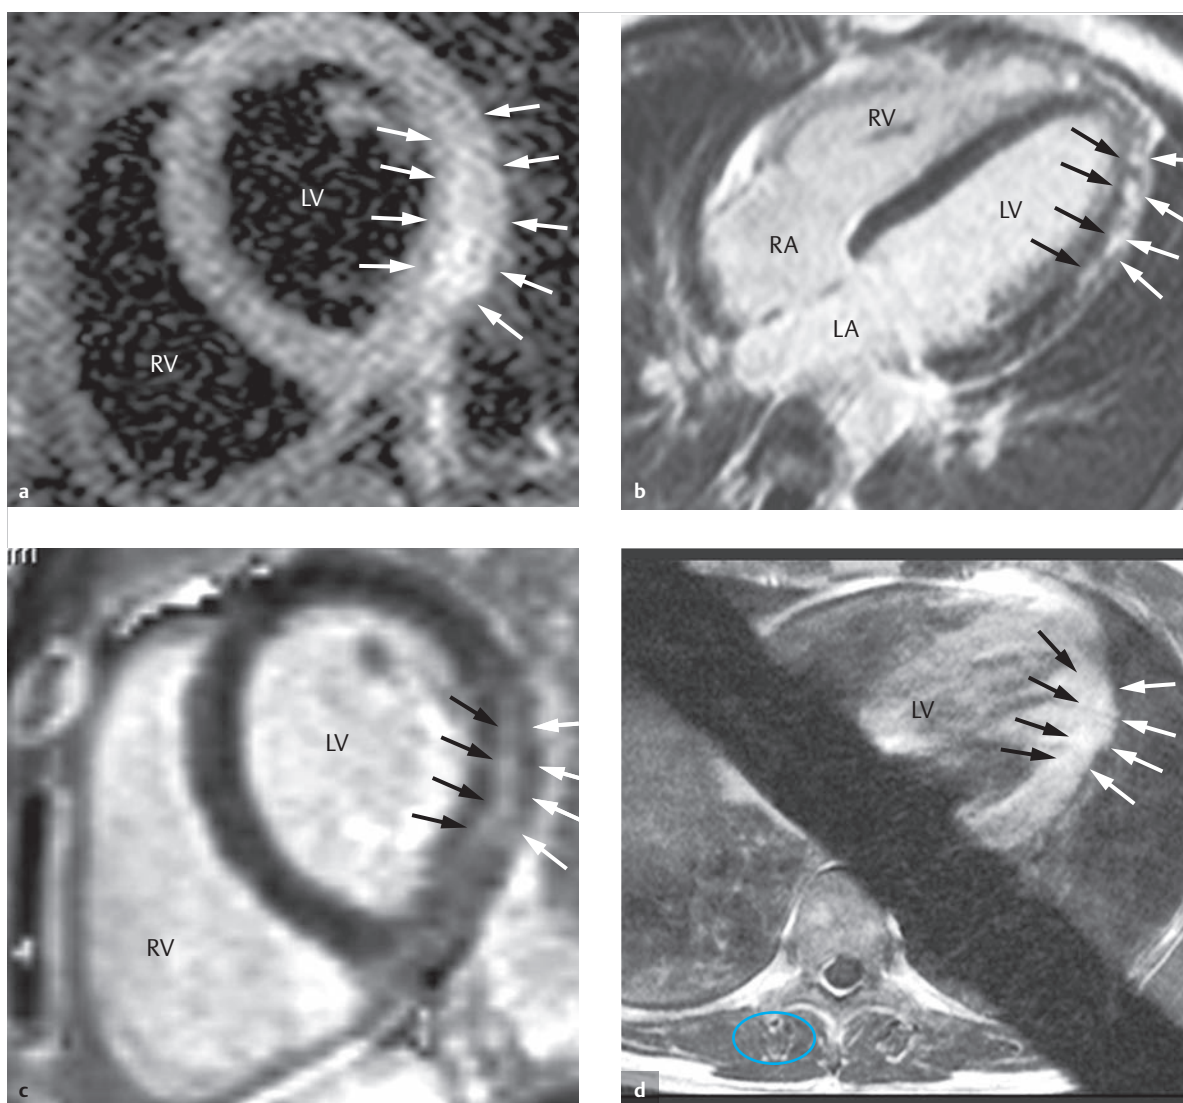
Acute myocarditis. Cardiac MRI of a 17-year-old male patient with acute chest pain and infarct-like myocarditis 10 days after an influenza infection: typical ST elevation, elevated troponin concentration, and apparent infection. TTE verifies pericardial effusion and normal left ventricular function.
